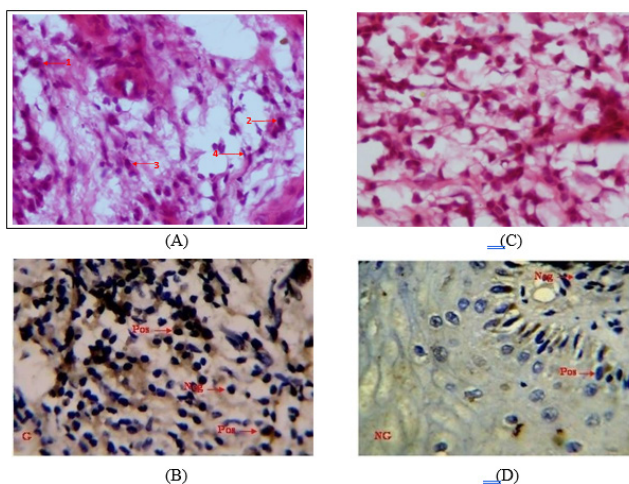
(A) Granuloma tissue (B) Non Granuloma (C) Periapical Granuloma (D) non Granuloma
